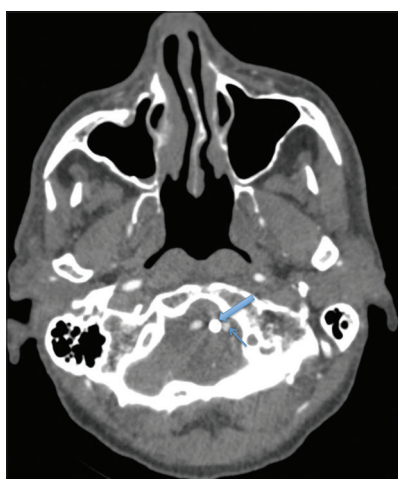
Axial computed tomography angiography sequence of the neck 7 months after anterior odontoid screw fixation demonstrating the odontoid screw (thick arrow) marginating the left vertebral artery (thin arrow).
